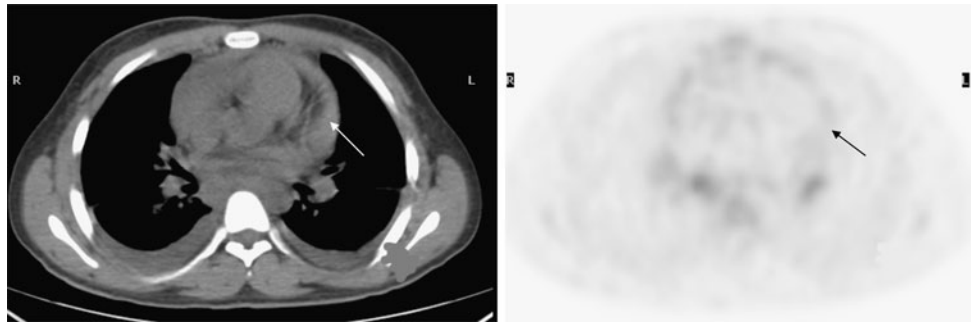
Pericarditis in a 18-year-old man with AIDS and FUO. Transaxial FDG PET-CT show moderate pericardial effusion with mild uptake (SUV 2.3) (arrows). Subsequent blood culture was positive for fungi. The pericardial effusion resolved after anti-fungal therapy
